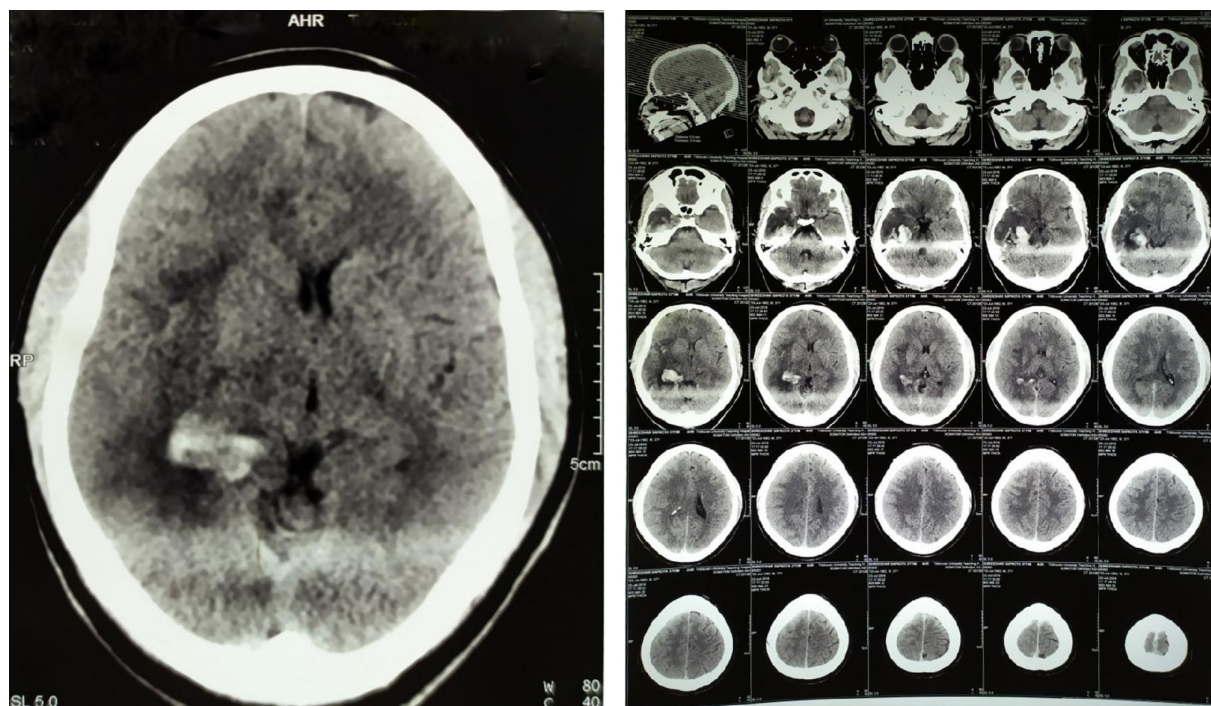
CT scan done on Day 6 of admission showing right temporal lobe hemorrhage.
